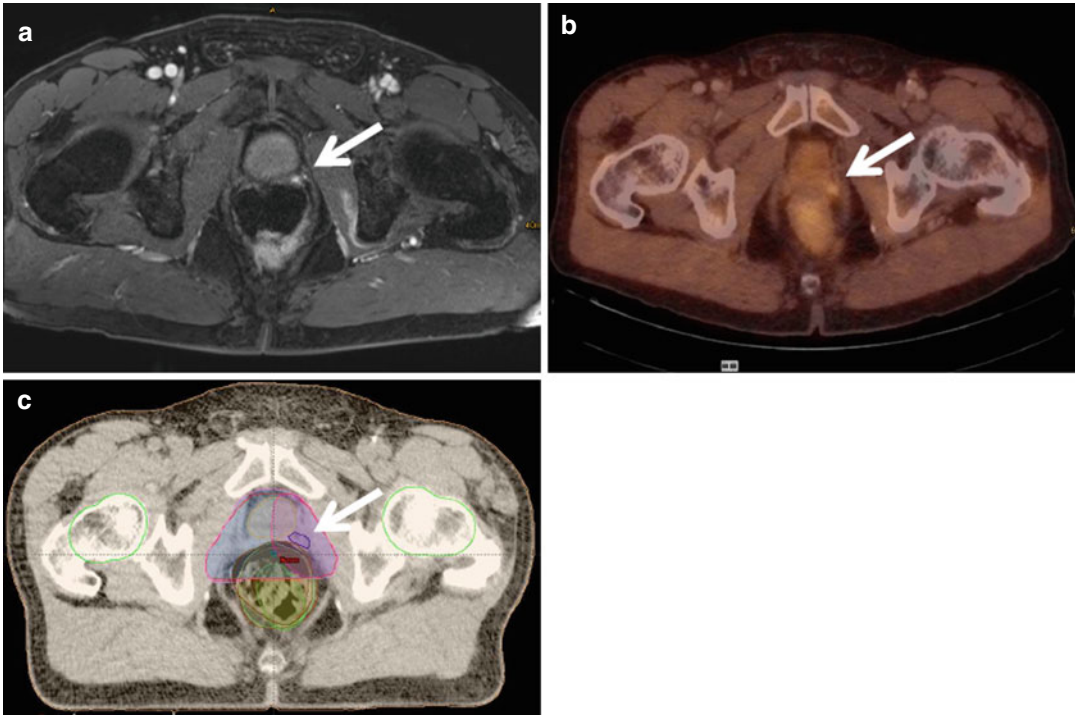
Imaging for radiotherapy planning of a patient with PSA recurrence of prostate cancer, 3 years after radical prostatectomy. (a) MRI scan (contrast-enhanced fatsat T1 sequence) with focal contrast enhancement (*arrow*) in the lateral aspect of the prostatic fossa. (b) 18-F-choline
